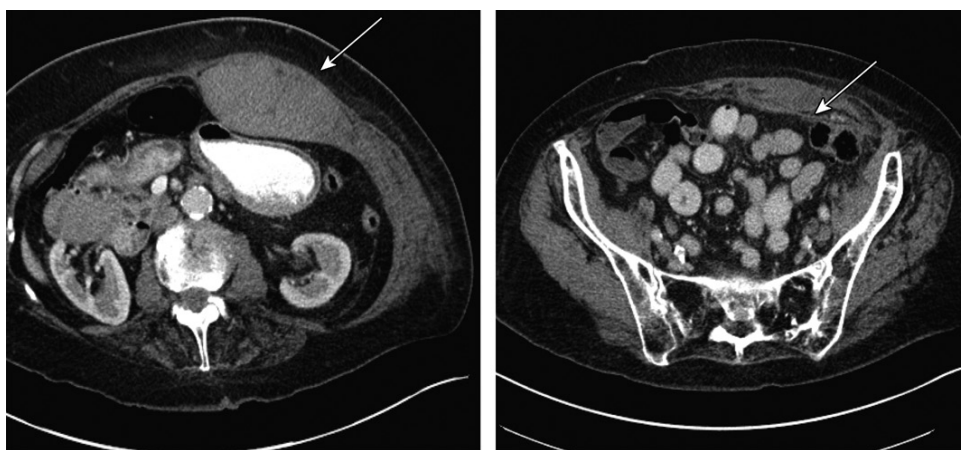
Shapes of RSHs occurring above and below the arcuate line of Douglas in an 82-year-old woman. (a) Axial CT image shows that an RSH above the arcuate line of Douglas tends to be spindle shaped and is supported posteriorly (arrow). (b) Axial CT image shows that an RSH below the arcuate line of Douglas is less organized (arrow) because of a lack of substantial posterior fascial support.
